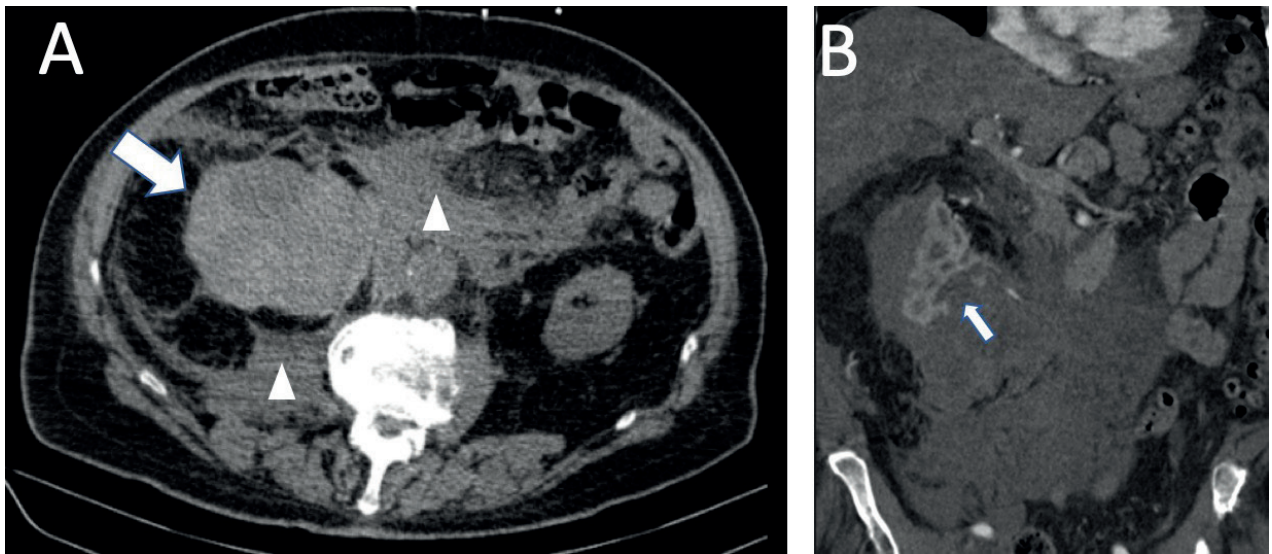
CT non-contrast image of a large subcapsular right renal haematoma (arrow in A) extending into the retroperitoneal space (arrowheads) with a large parenchymal laceration showed in the venous phase in the coronal multiplanar reconstruction (arrow in B).
